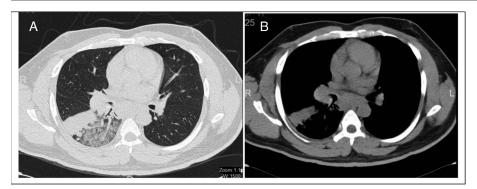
A, B, Chest CT scan. A, Parenchymal window. Multisegmental consolidation of right lower lobe with obstructing lesion in right lower lobe bronchus. B, Mediastinal window. Globular-shaped dense structure obstructing right lower lobe bronchus with relative enhancement and right hilar lymphadenopathy.
